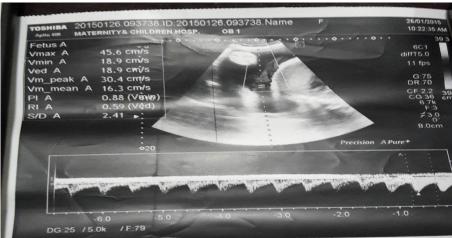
shows normal Color Doppler of the umbilical artery waveform at 39 Wks .
